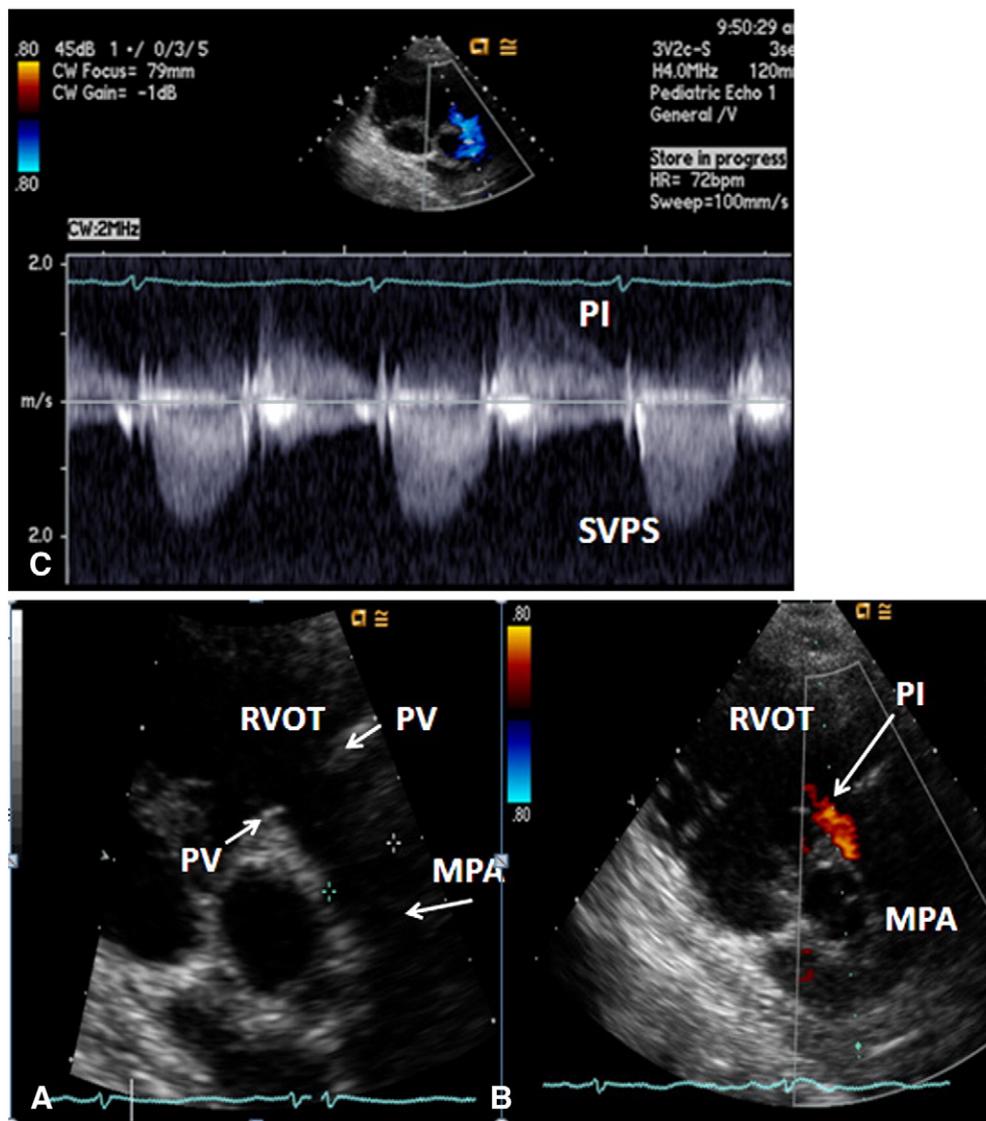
Echo-Doppler studies performed five months after removal of the Nuss bar. (A) Selected video frame from a precordial short axis view of the heart demonstrating no echo dense structures in the right ventricular outflow tract (RVOT) and main pulmonary artery (MPA). Pulmonary valve (PV) leaflets (arrows) are shown. (B) Color Doppler mapping of the same structures as in panel A shows pulmonary insufficiency (PI) (arrow). (C) Continuous wave Doppler sampling demonstrating low Doppler flow velocity across the MPA with a calculated peak instantaneous gradient of 15 mmHg, indicating minimal supra-ventricular pulmonary stenosis (SVPS) and pulmonary insufficiency (PI).
